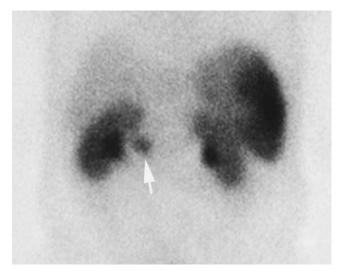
Somatostatin receptor scintigram showing isotope uptake by a gastrinoma (*arrow*). On exploration, the tumor was found in the duodenum. The large enhancing area on the right of the figure is the spleen.
